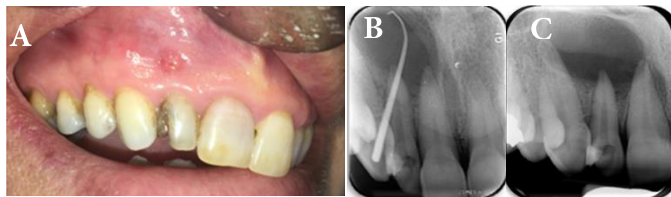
A) The sinus tract is seen near the lateral tooth; B) Tracing the sinus tract with gutta-percha revealed the lesion was associated with tooth #7; C) Periapical radiograph showing a round radiolucent lesion extending from the mesial aspect of tooth #6 to the distal aspect of tooth #8
